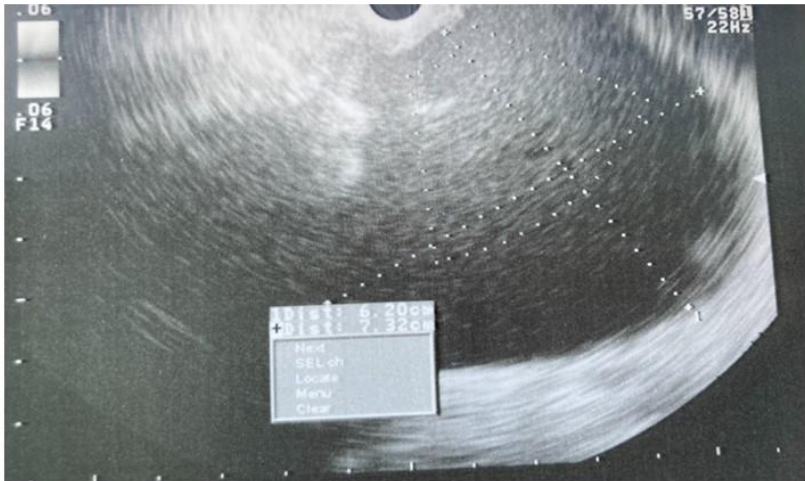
Endoscopic Ultrasound (EUS)-guided cysto-gastrostomy
